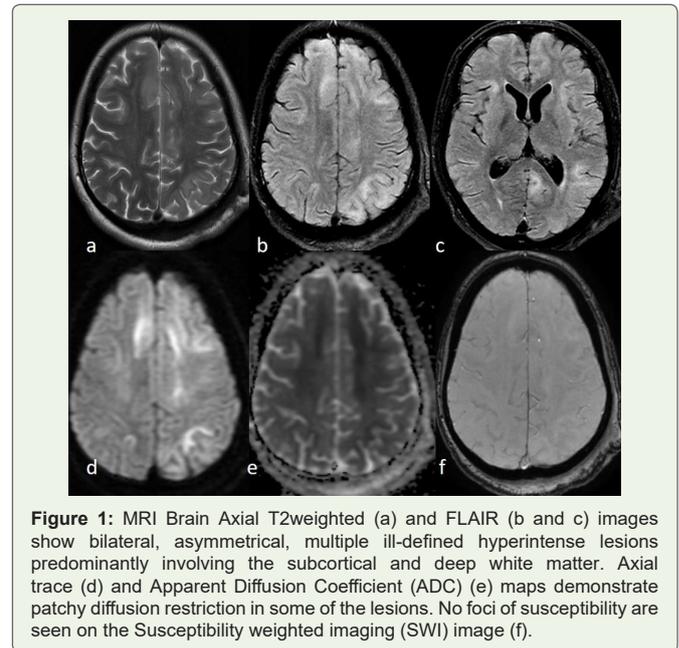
MRI Brain Axial T2weighted (a) and FLAIR (b and c) images show bilateral, asymmetrical, multiple ill-defined hyperintense lesions predominantly involving the subcortical and deep white matter. Axial trace (d) and Apparent Diffusion Coefficient (ADC) (e) maps demonstrate patchy diffusion restriction in some of the lesions. No foci of susceptibility are seen on the Susceptibility weighted imaging (SWI) image (f).
